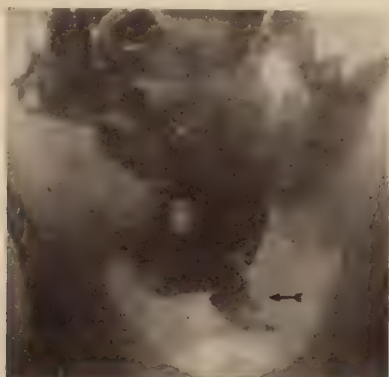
Radiograph taken two hours after barium meal. No barium has reached the cecum. Diverticulum projects downward and has a filling defect in its tip and two lateral incisures (site of the ulcers).
